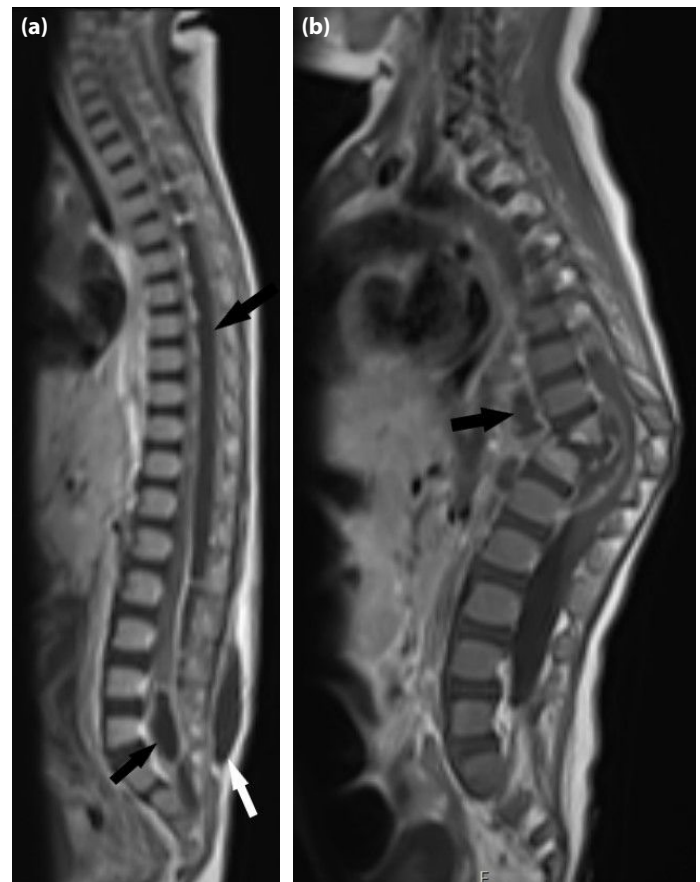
(a) MRI of an 18-year-old girl with spinal arachnoiditis. Contrast-enhanced T1-weighted sagittal spinal MRI reveals an epidural abscess surrounding the spinal cord and thecal sac (black arrows), with a soft tissue abscess in the lumbar subcutaneous area (white arrow). (b) MRI of a 3-year-old girl with TB spondylitis. Contrast-enhanced T1-weighted sagittal spinal MRI shows low thoracic involvement, with vertebral destruction and relatively preserved disc spaces. A paravertebral abscess is also visible (arrow).
